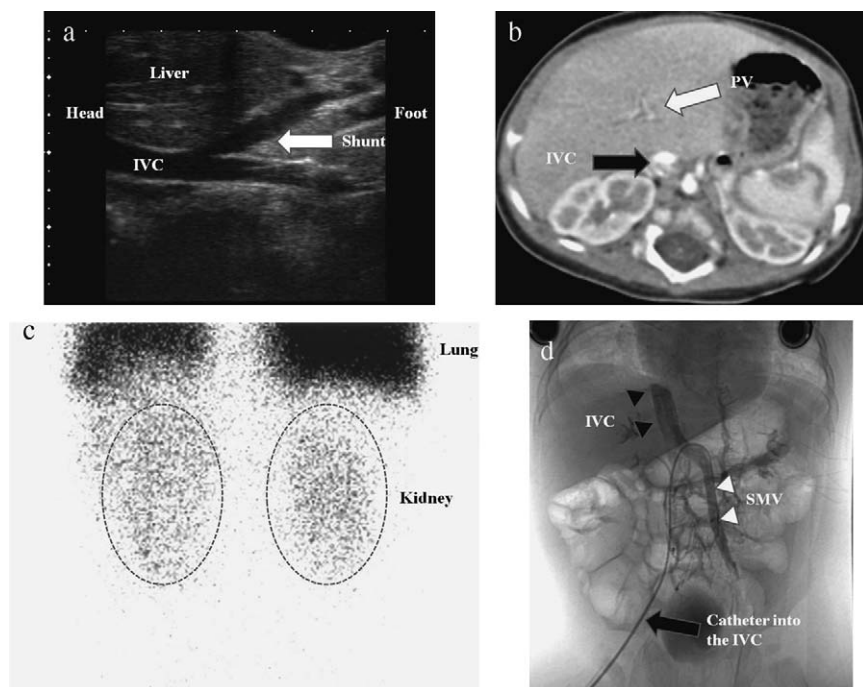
Extrahepatic portosystemic shunt with portal vein hypoplasia. (a) Extrahepatic portal vein (PV)–inferior vena cava (IVC) shunt was clearly demonstrated on sagittal view on ultrasonography. (b) Contrast-enhanced computed tomography also demonstrated the lesion. (c) Lung perfusion scintigraphy with ^{99m}Tc macroaggregated albumin demonstrated pulmonary arteriovenous shunt at 1 year of age. (d) Angiography confirmed the diagnosis of portosystemic shunt. Also note hypoplastic portal vein. SMV, superior mesenteric vein.
